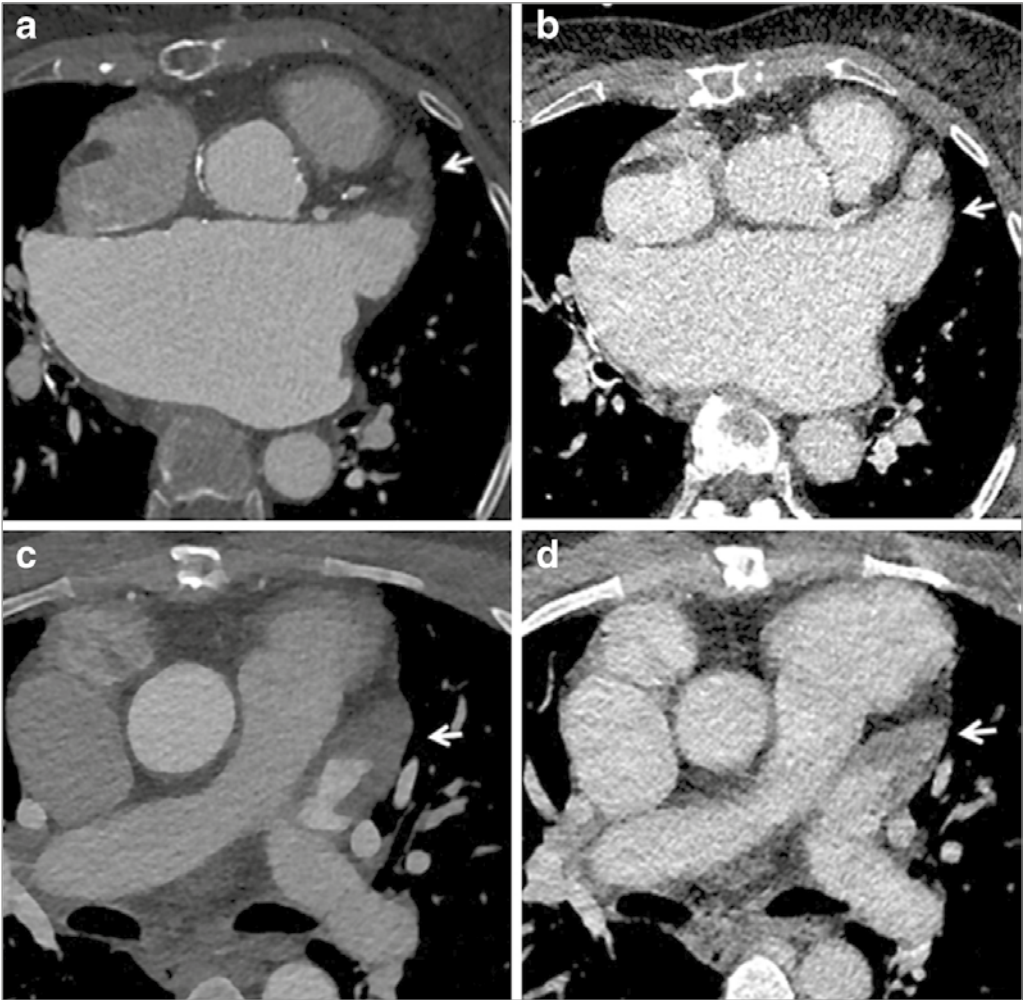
One of the advantages of the delayed scan acquisition is the ability to better depict thrombus and differentiate thrombus from flow artefacts, since patients with a prosthetic heart valve often have arrhythmias. In the first patient (A-B), the arterial CT angiography (CTA) acquisition (A) depicts a filling defect in the left atrial appendage (arrow). The delayed scan (B) shows that it involved a flow artefact with good filling of the left atrial appendage in this phase (arrows). Thrombus could thus be excluded. In the second patient (C-D), the arterial CTA acquisition (C) also depicts a filling defect in the left atrial appendage (arrow). However, in this case, the delayed scan (D) confirms the presence of a thrombus (arrow).
